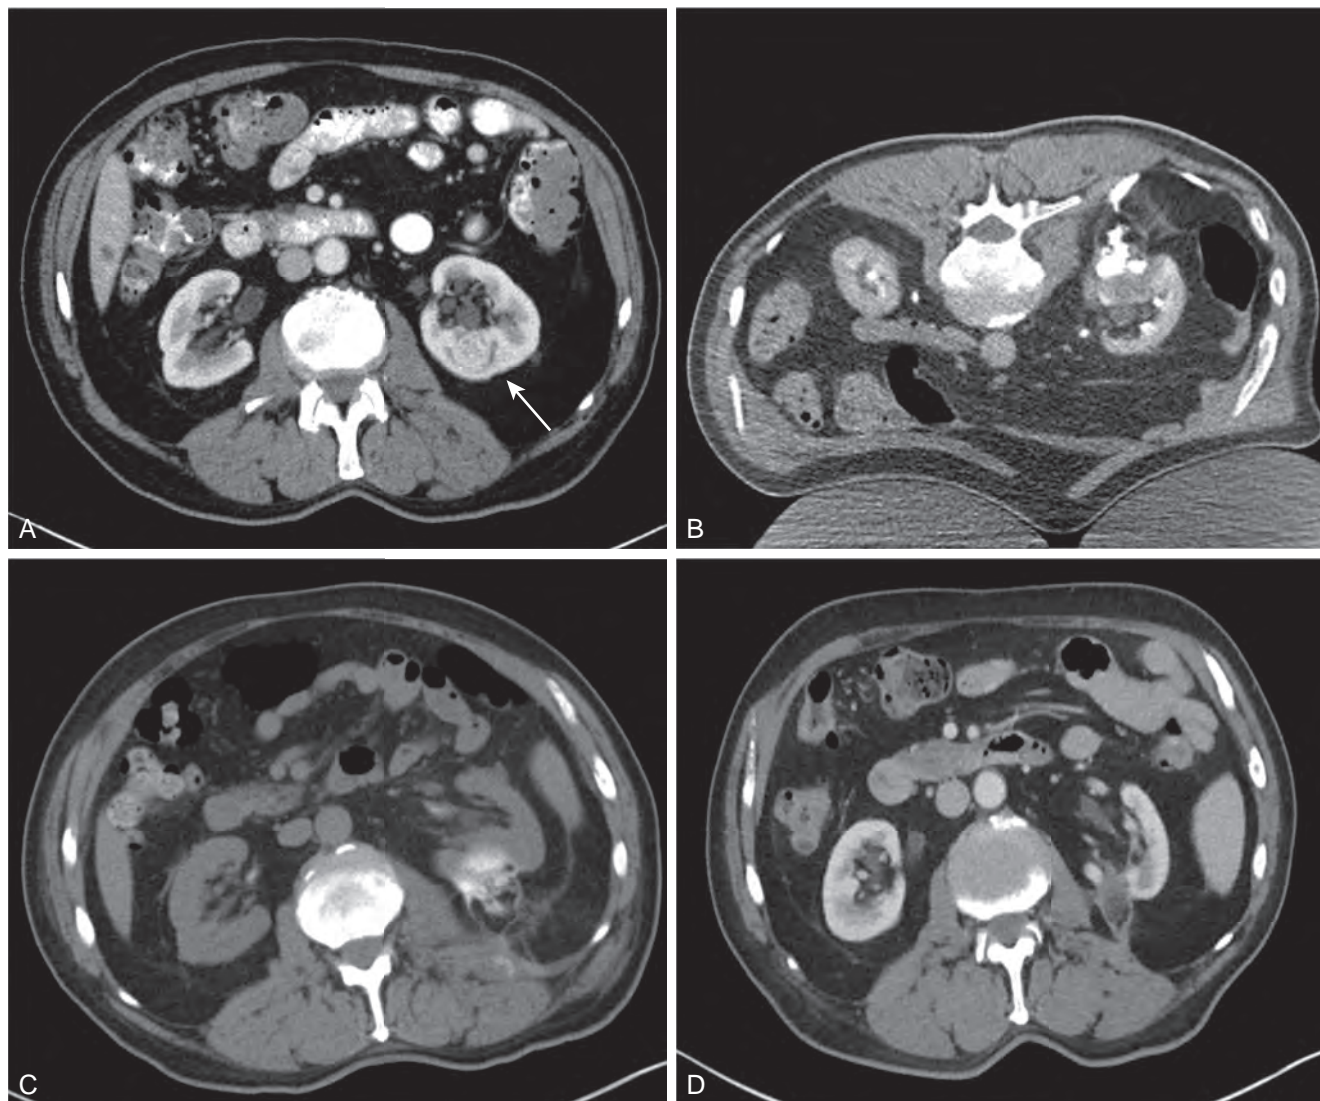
Urine leak after percutaneous radiofrequency ablation (RFA). A, Preoperative imaging shows 2.5-cm endophytic left renal mass (*arrow*). B, Immediate postoperative image after ablation shows urinary extravasation at the site of RFA. C, Postoperative day 1 computed tomography (CT) image shows no change in the fluid collection. D, Three-year follow-up CT shows involution of the treated area with postoperative halo.
